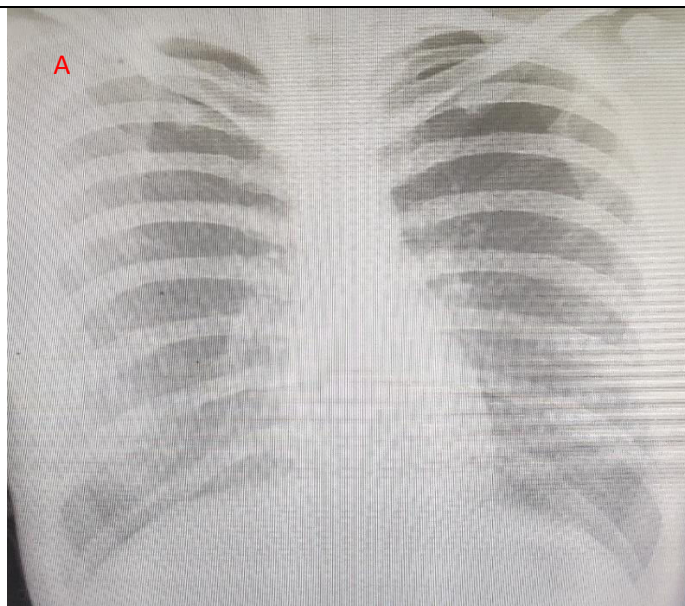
A radiograph of a male before the application of Image enhancement tools. B: Enhanced Image
